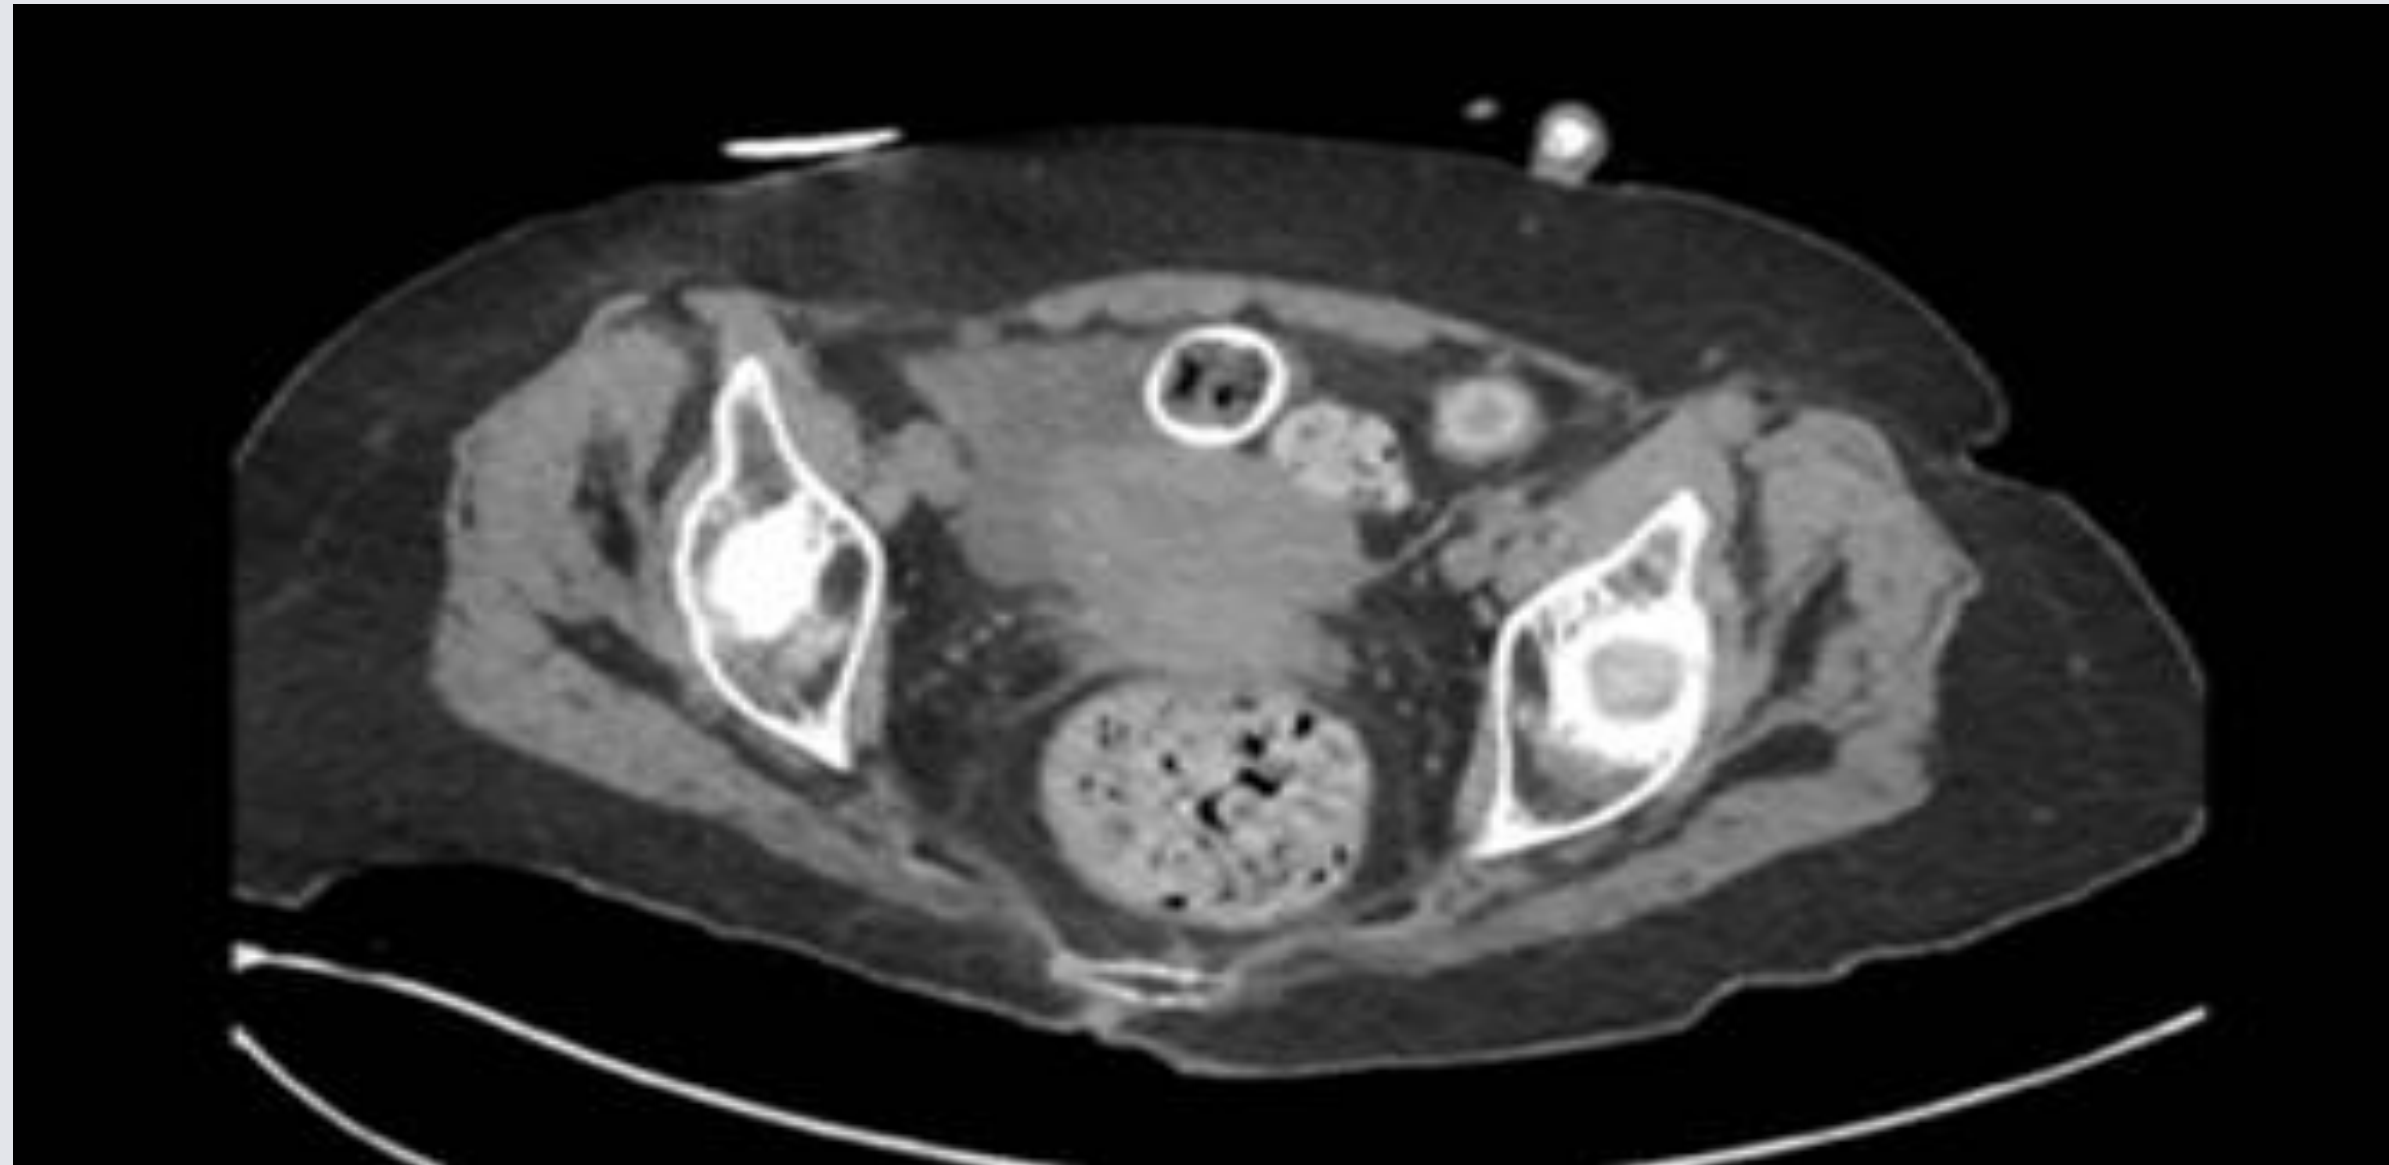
CT scan showing retained PEG Tube
